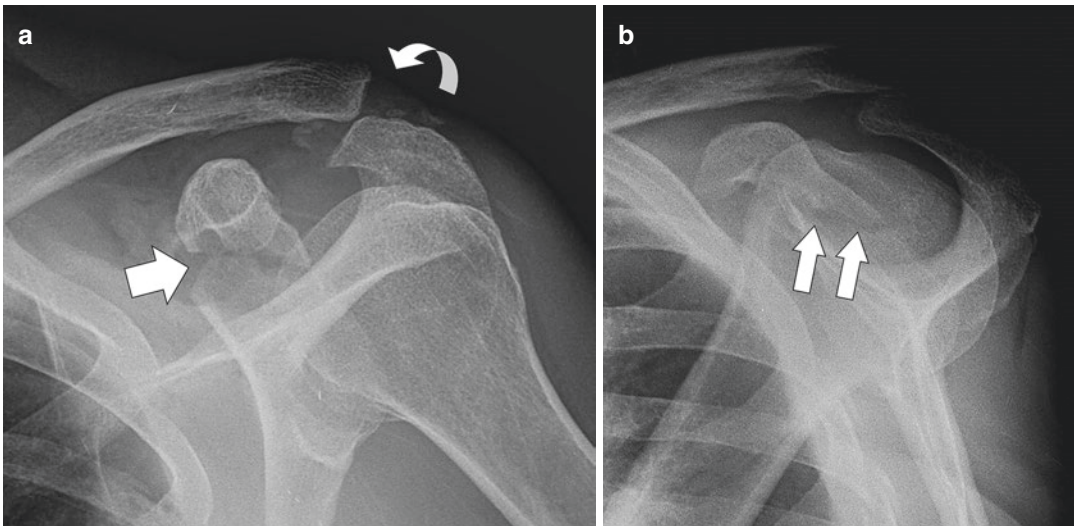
Coracoid fracture, type 1. (a) Frontal radiograph shows cortical disruption near the base of the coracoid process (arrow). There is also a type 3 AC separation (curved
